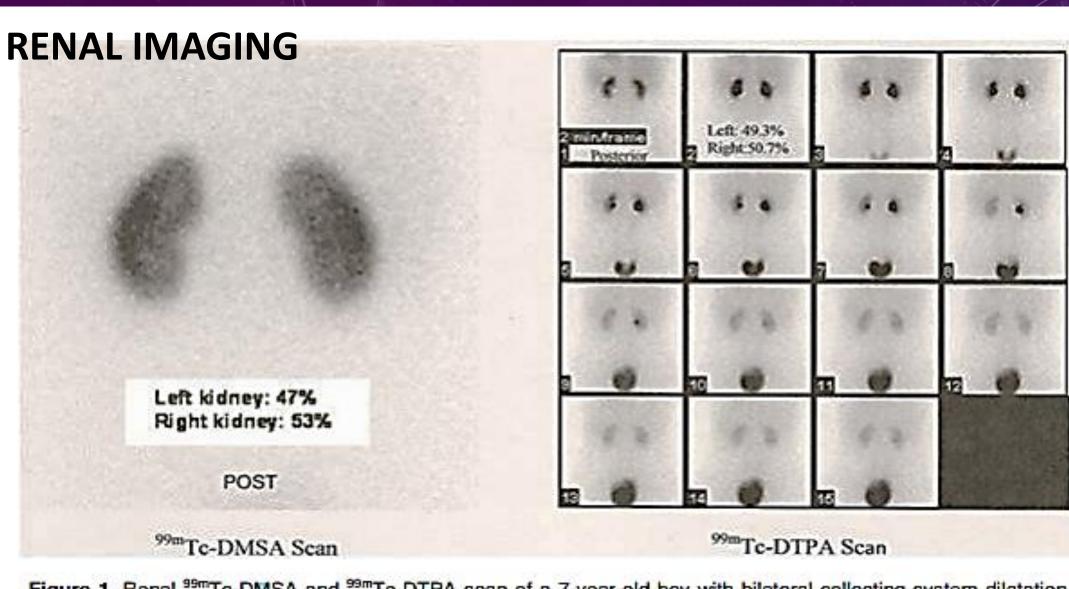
Renal ^{99m}Tc-DMSA and ^{99m}Tc-DTPA scan of a 7-year-old boy with bilateral collecting system dilatation on ultrasonography.
